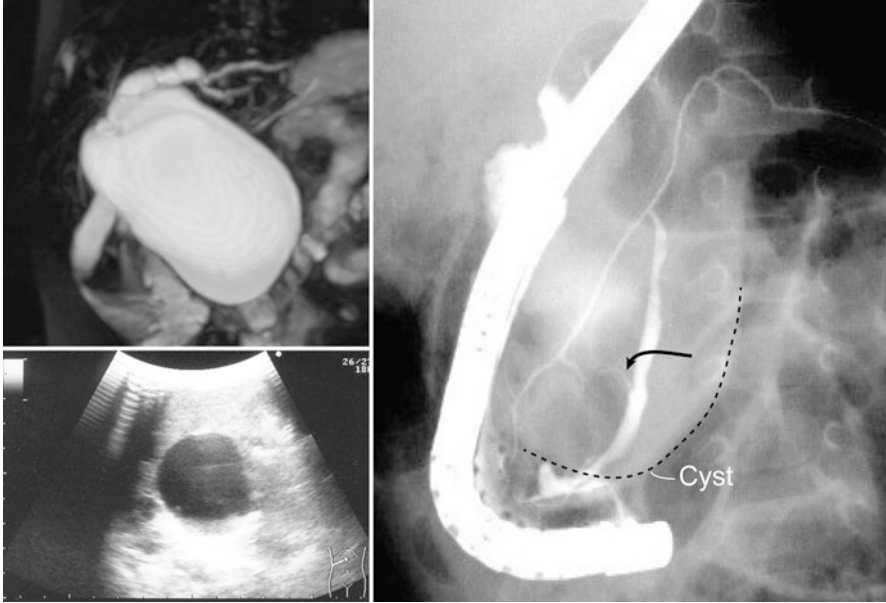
Representative case with congenital biliary dilatation diagnosed prenatally. Magnetic resonance cholangiography after birth showed large cystic dilatation of the common bile duct, but pancreaticobiliary junction was obscure (*left upper*). One month after birth, acholic stool and mild jaundice with elevated levels of transaminase developed, when ultrasonography detected debris in the dilated bile duct (*lower left*). Serum levels of amylase and lipase were not elevated. At 5 months when symptoms subsided, endoscopic retrograde cholangiopancreatography showed pancreatico-biliary maljunction with a thin hairlike duct (*arrow*) connecting the main pancreatic duct and the cyst (*right*). The main pancreatic duct described an arc pushed by a large cyst
